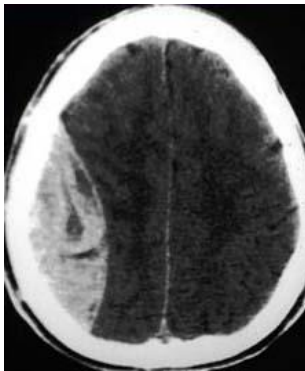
CT scan of a massive extradural haematoma
